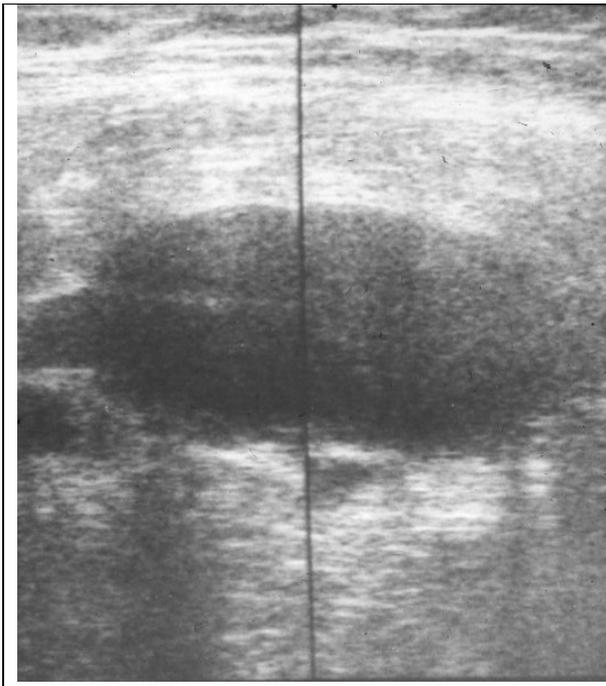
Ultrasound examination of abdomen cavity.
